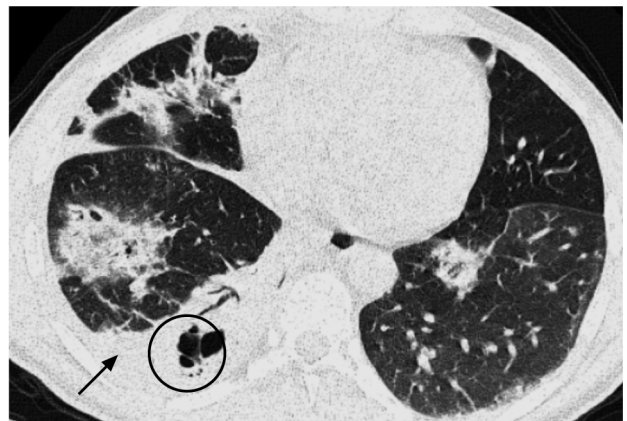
A 57-year-old male patient was hospitalized for COVID-19 pneumonia 12 days after a progressive course of increasing dry cough, generalized weakness and fever (severe clinical presentation). Non contrast CT chest axial cuts revealed that the posterior basal segment of the right lung lower lobe shows consolidation (arrow) along with cavitation (circle) associated with patches of GGO and crazy paving of both lower lung lobes and right middle lung lobe and right fissure thickening. CT findings were consistent with CORADS 5. Chest CT severity score was 10. Initially, the patient was isolated in a regular ward. On the 12th day of the clinical course, oxygen saturation dropped to 78% and ICU admission was decided. The patient was returned to the regular ward after ten days and discharge was decided therefore.
